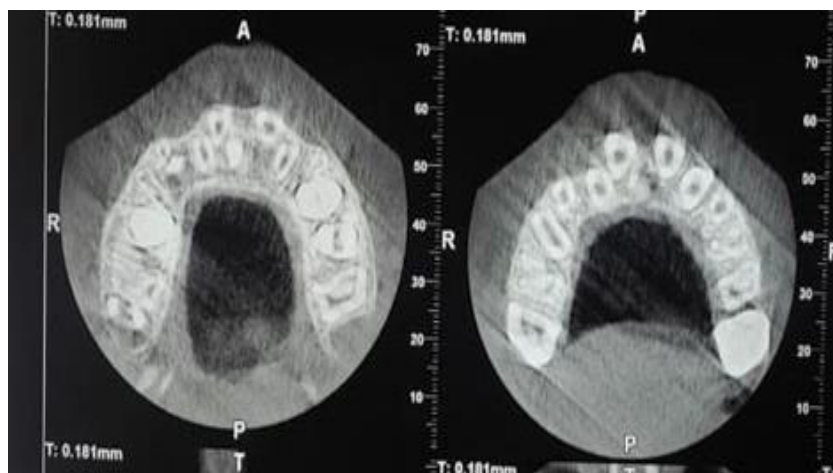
Pre-operative CBCT reveals impacted supernumerary teeth with rotated 21teeth located palatal to the incisors (palatal view)
